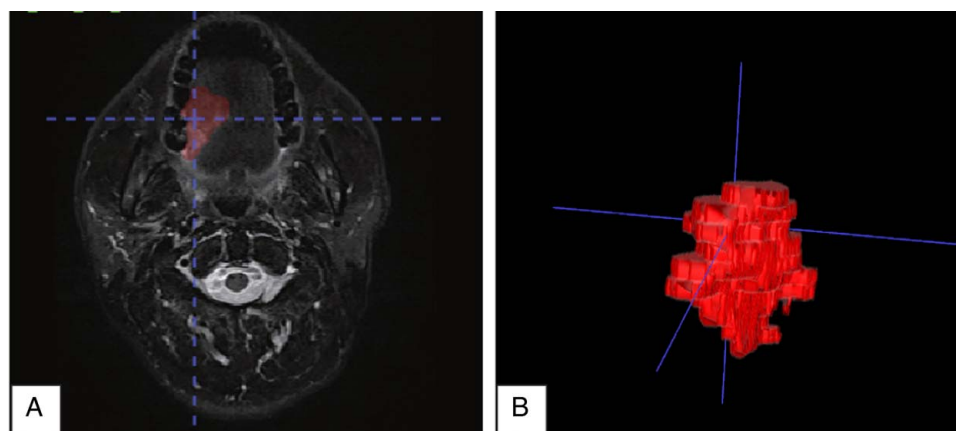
Tumor segmentation. A. The MRI image was marked manually for the tumor; B. The three-dimensionally reconstructed tumor.
